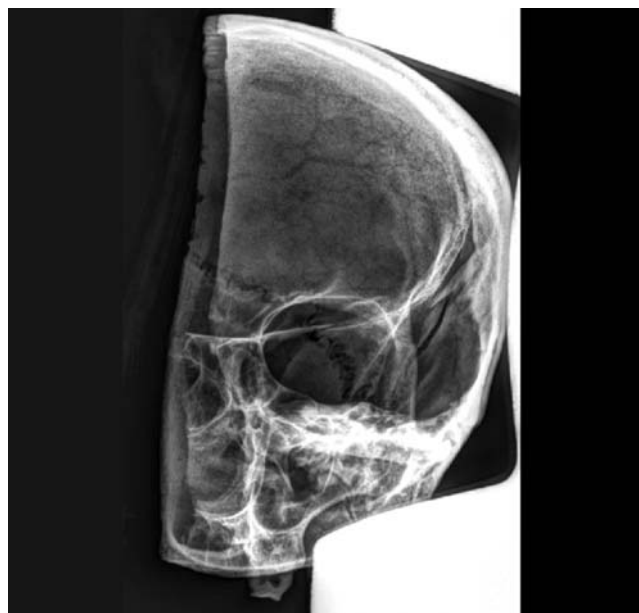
Unilateral foramen rotundum in ethmoidal cells on X-ray.
